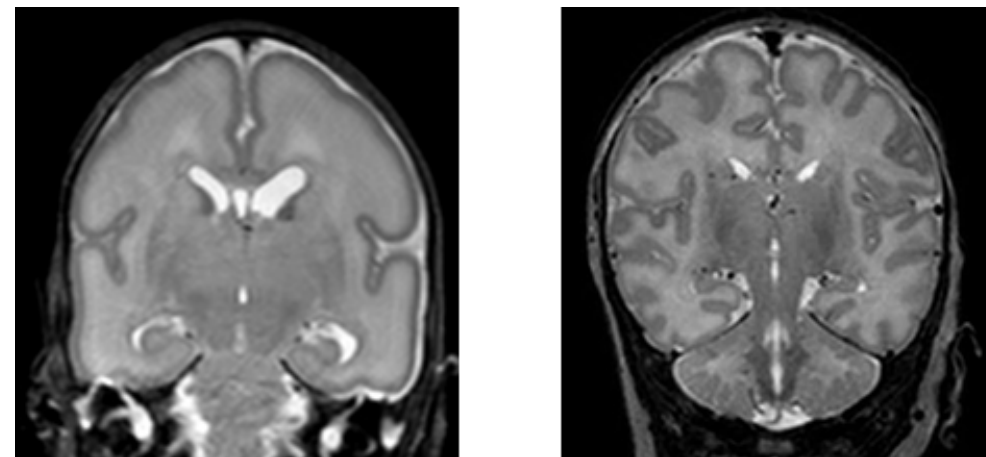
Brain development. T₂ MRI scans of an infant of 30 weeks GA of the left, and 40 weeks GA on the right. Noteworthy is the increase in volume, myelination, gyri- and sulcification.
